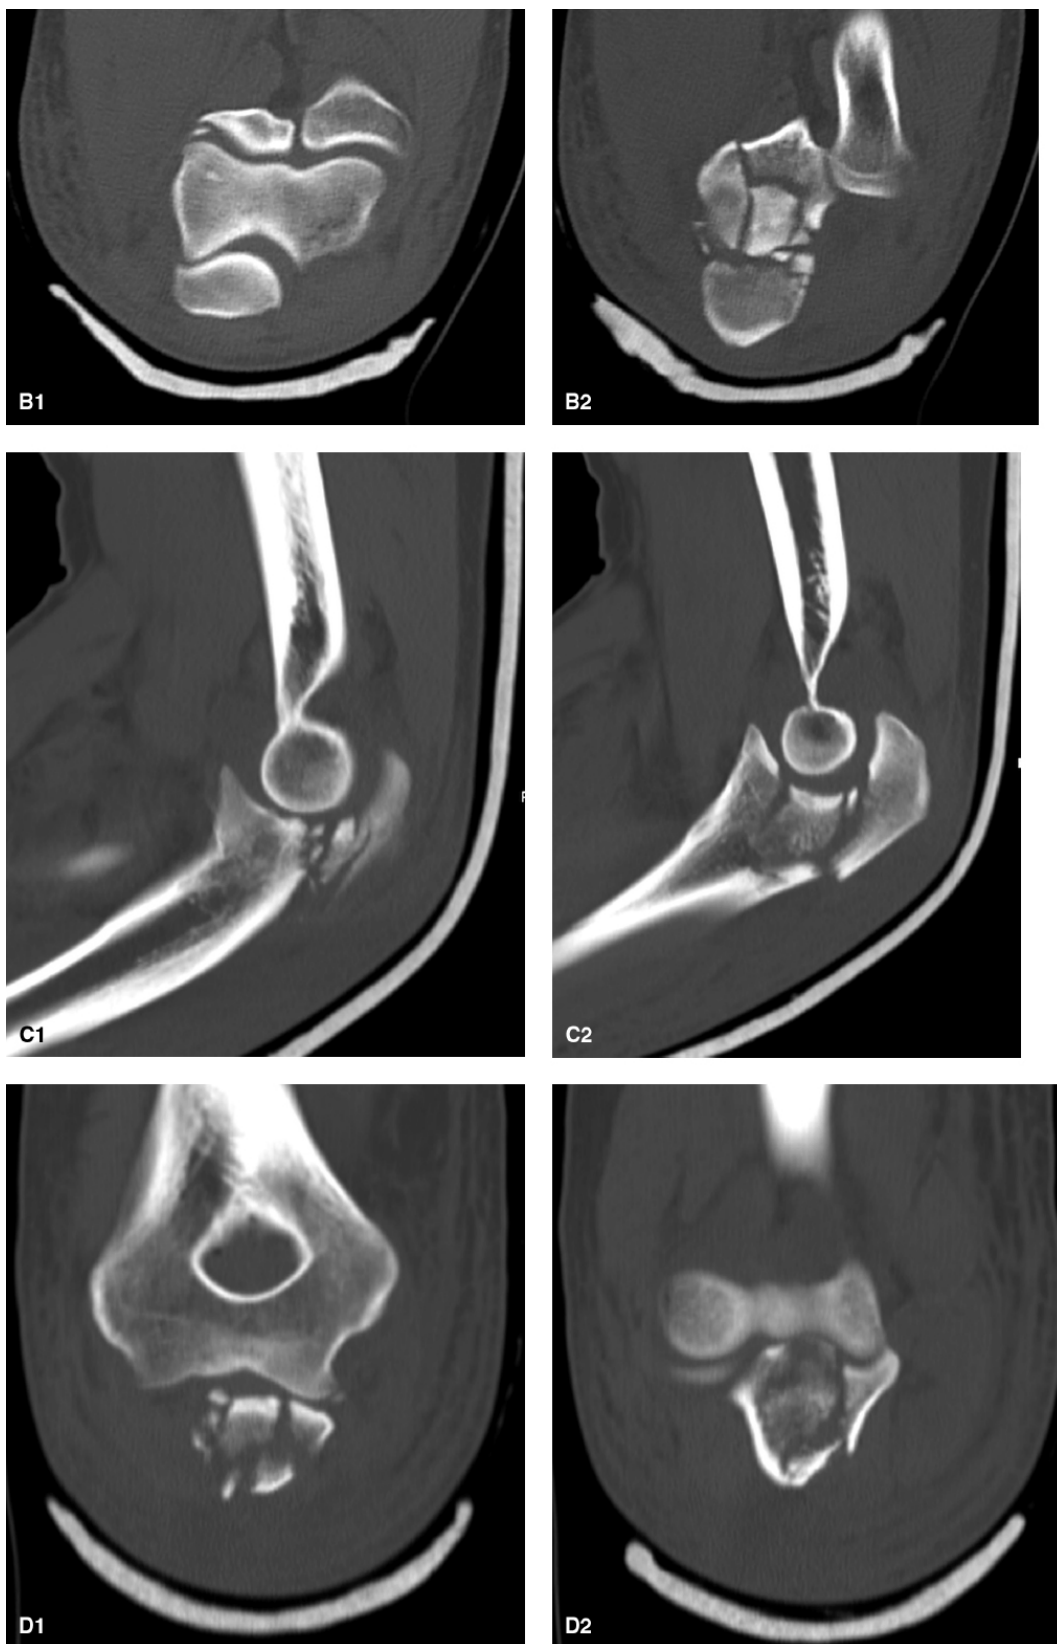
A: CT 3D reconstruction. B1: Axial cuts in the plane of the distal
